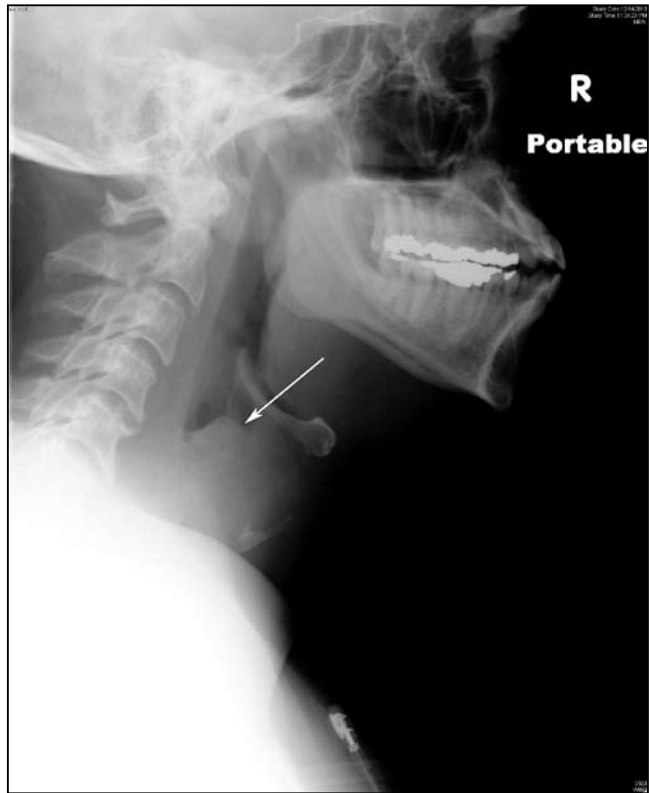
A lateral radiograph of the neck demonstrates marked soft tissue swelling and possible mass in the infrahyoid region (arrow), with narrowing of the trachea.
